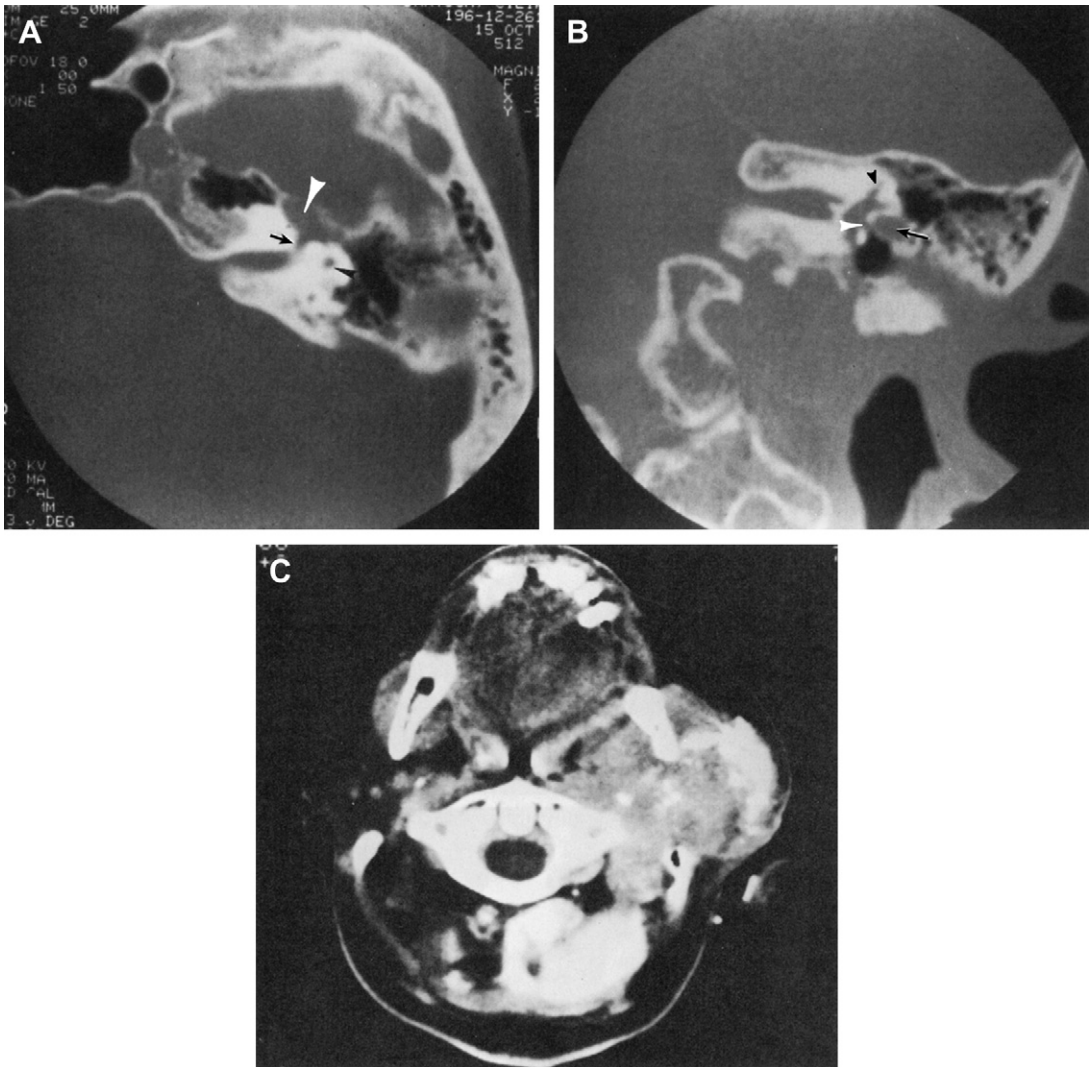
Perineural extension along the facial nerve canal. Patient has parotid mass and facial paralysis. (A) There is enlargement of the geniculate ganglion (*white arrowhead*) with slight enlargement of the labyrinthine segment of the facial nerve canal (*arrow*). Superior semicircular canal (*black arrowhead*). (B) Coronal image shows enlargement of the tympanic segment of the facial nerve canal (*arrow*). Normal structures; oval window (*white arrowhead*), superior semicircular canal (*black arrowhead*). (C) Computed tomography sialogram. Inferior slice shows a large tumor in the parotid gland.
